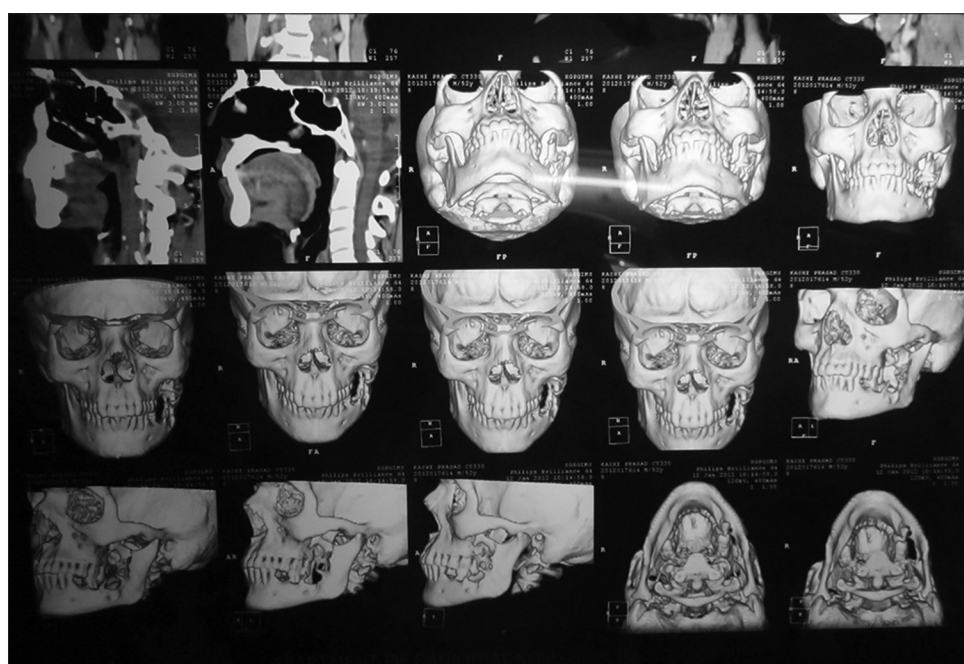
Three-dimensional computed tomography scan
